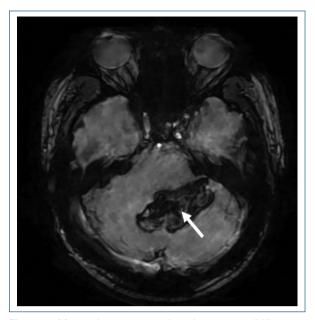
Magnetic resonance imaging susceptibility sequence showing hemorrhage in the left cerebellar parenchyma involving the vermis, as well as IV ventricle obliteration (arrow).
